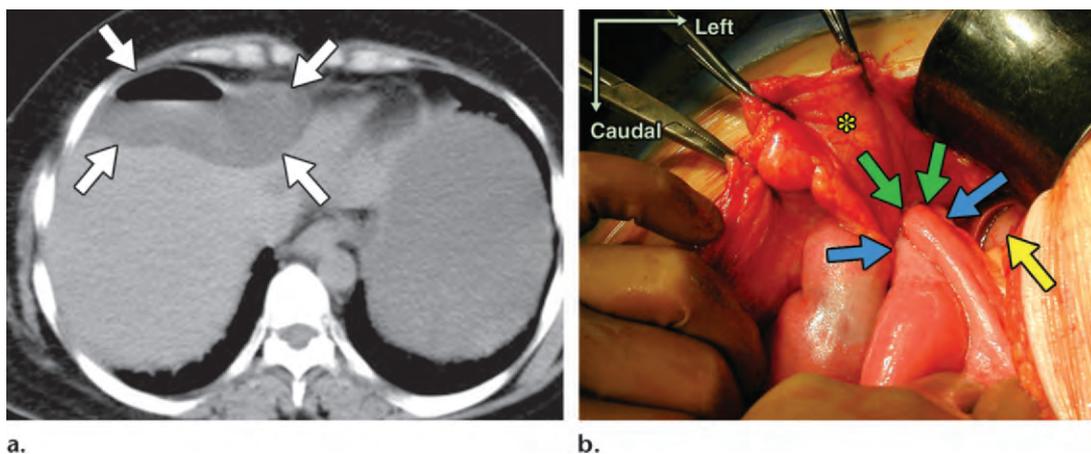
Falciform ligament hernia in a 40-year-old woman with a 6-day history of abdominal pain and vomiting. (a) Axial nonenhanced CT image shows incarcerated intestine (arrows) in front of the anterior and medial segments of the liver. (b) Intraoperative photograph (anterior view) shows incarceration of the intestine (blue arrows) through a small defect (green arrows) in the falciform ligament (*) of the liver. The herniated intestine was viable and was not resected. The falciform ligament was sectioned. Yellow arrow = lateral segment of the liver.
